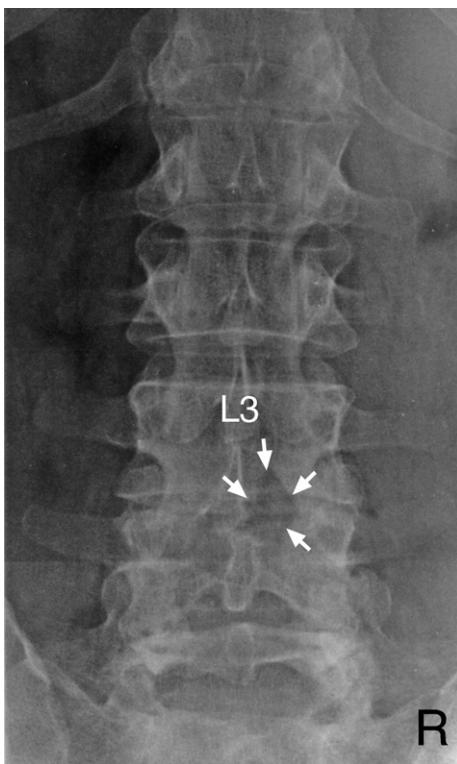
Lumbosacral spine erect posture anteroposterior plain X-ray image. Note the right sided L3–4 hemilaminectomy (arrows). L3 = L3 vertebral body; R = right side of patient.
